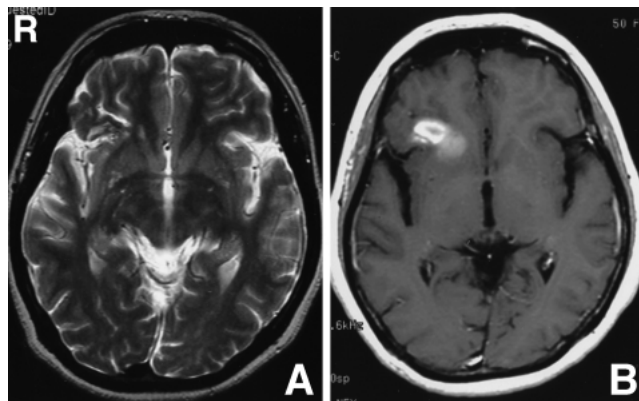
T₂-weighted magnetic resonance image obtained 2 months before the ictus showing a capillary high intensity area within the treated nidus (A). Gadolinium-enhanced T₁-weighted image obtained 10 days after the ictus showing the known hemorrhage without enhancement (B).
